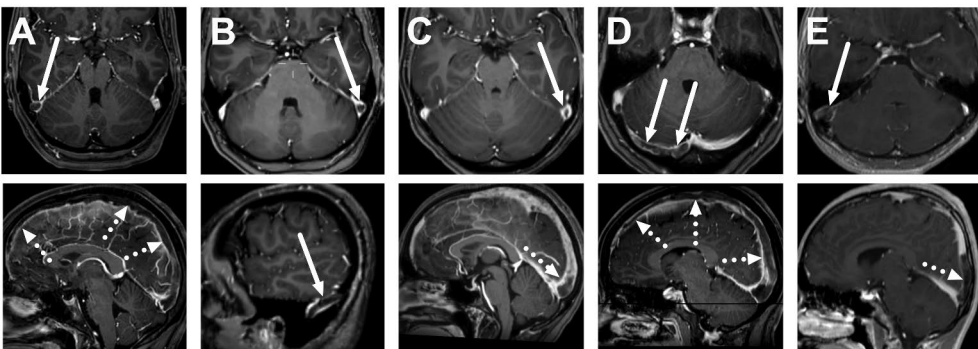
True positive cases of cerebral venous sinus thrombosis. Axial (top row) and sagittal (bottom row) images of post-gadolinium T1-weighted 3D MRI images of five patients: a 26-year-old female (A), a 33-year-old female (B), a 21-year-old female (C), a 27-year-old female (D), and a 16-year-old male (E). Thrombosis is seen as a hypointense filling defect against the high signal from the gadolinium-based contrast agent in the venous sinuses, usually in the transverse sinuses (arrows) and the superior sagittal sinus (dotted arrows).
